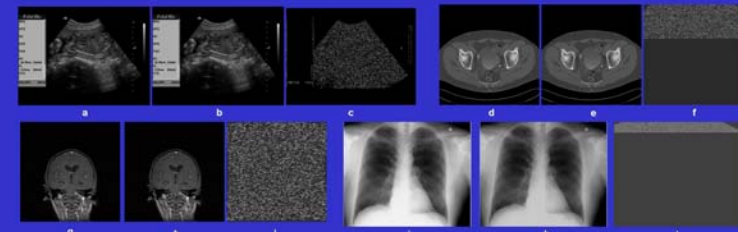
a: original US image, b: image signature embedded US image, c: subtracted image between b and a showing the embedded bits in the embedded image b; d: original CT image, e: signature embedded CT image, f: subtracted image between e and d; g: original MR image, h: signature embedded MR image, i: subtracted image between g and h; j: original CR image, k: signature embedded CR image, l: subtracted image between k and j.
